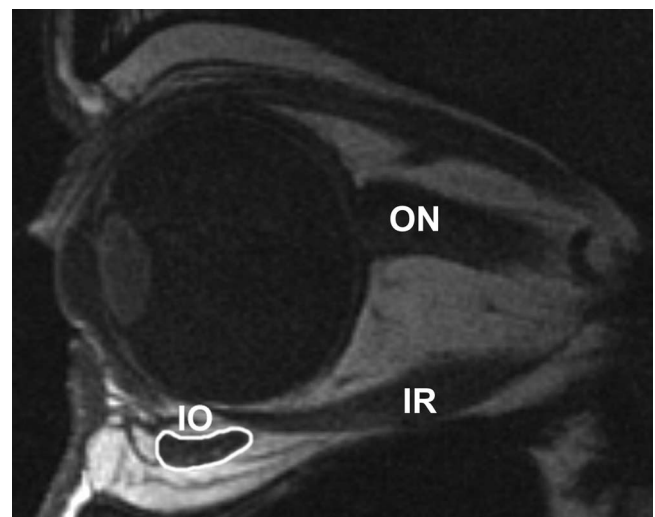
Quasi-sagittal MRI of right orbit in a subject with right BrS. IR, inferior rectus muscle; ON, optic nerve.
